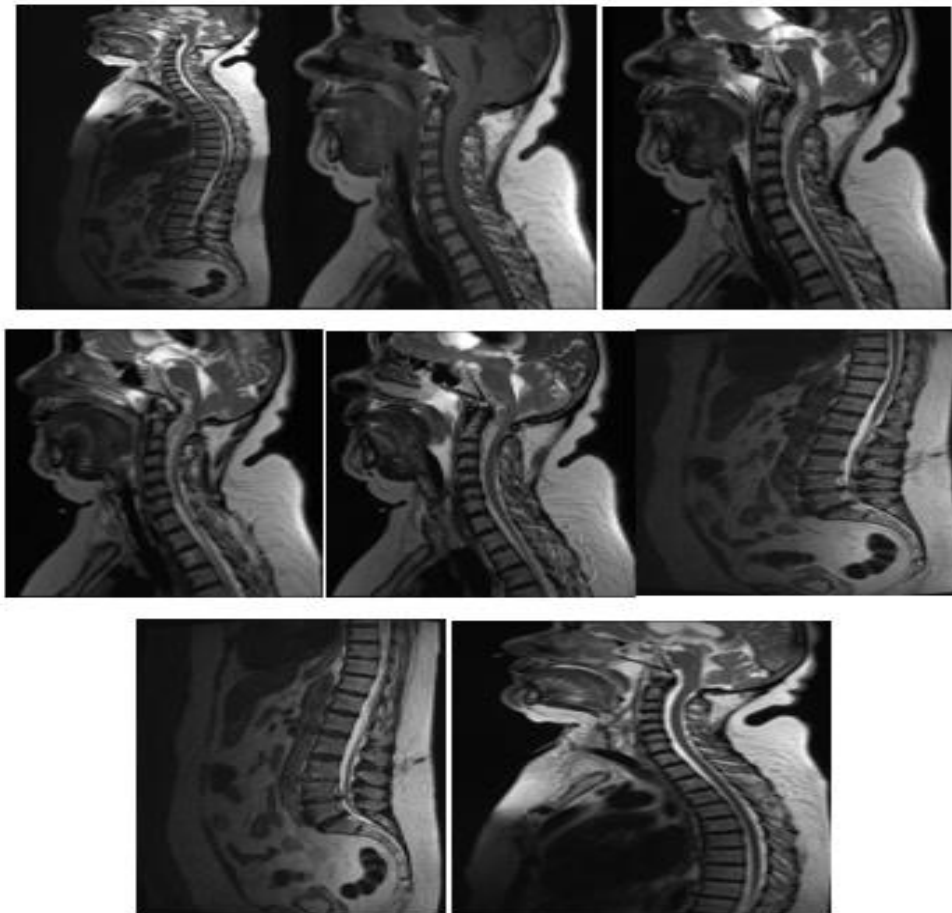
MRI spine, different sequences (T1, T2, DWI) of the case No (1).
